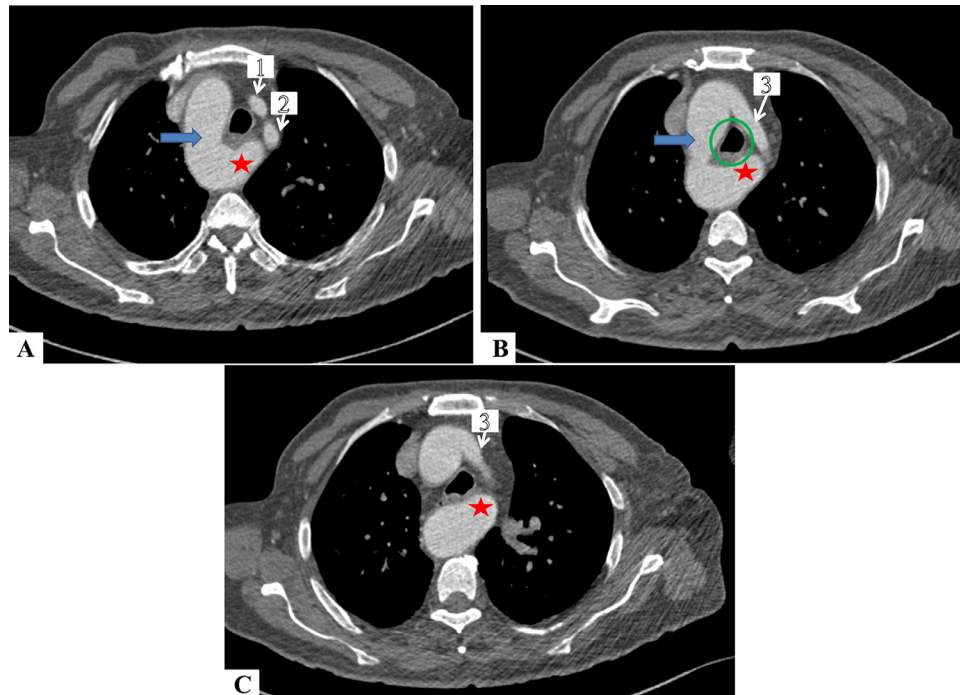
Axial contrast-enhanced CT images (A-C) showing a large aortic diverticulum (red asterisk) along with the right-sided aortic arch (blue arrow) forming a vascular ring (green circle) with the left brachiocephalic artery, and causing mild extrinsic compression of the trachea and esophagus. (1): left common carotid artery; (2): left subclavian artery; (3): left brachiocephalic trunk.
